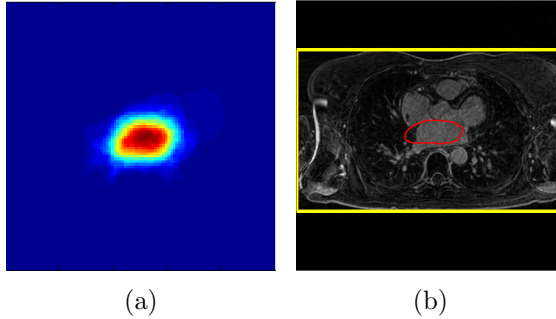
(a) Spatial distribution of the LA in the normalized coordinate system.(b) The ROI (yellow) of an MR image and applied LA mask(red).
